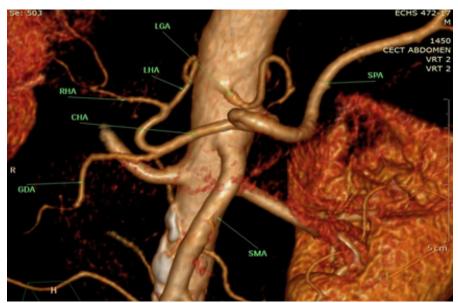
CT Angiogram, volume rendered image showing Hepatosplenic trunk withseparate origin of Left Gastric artery and Superior Mesenteric artery.
